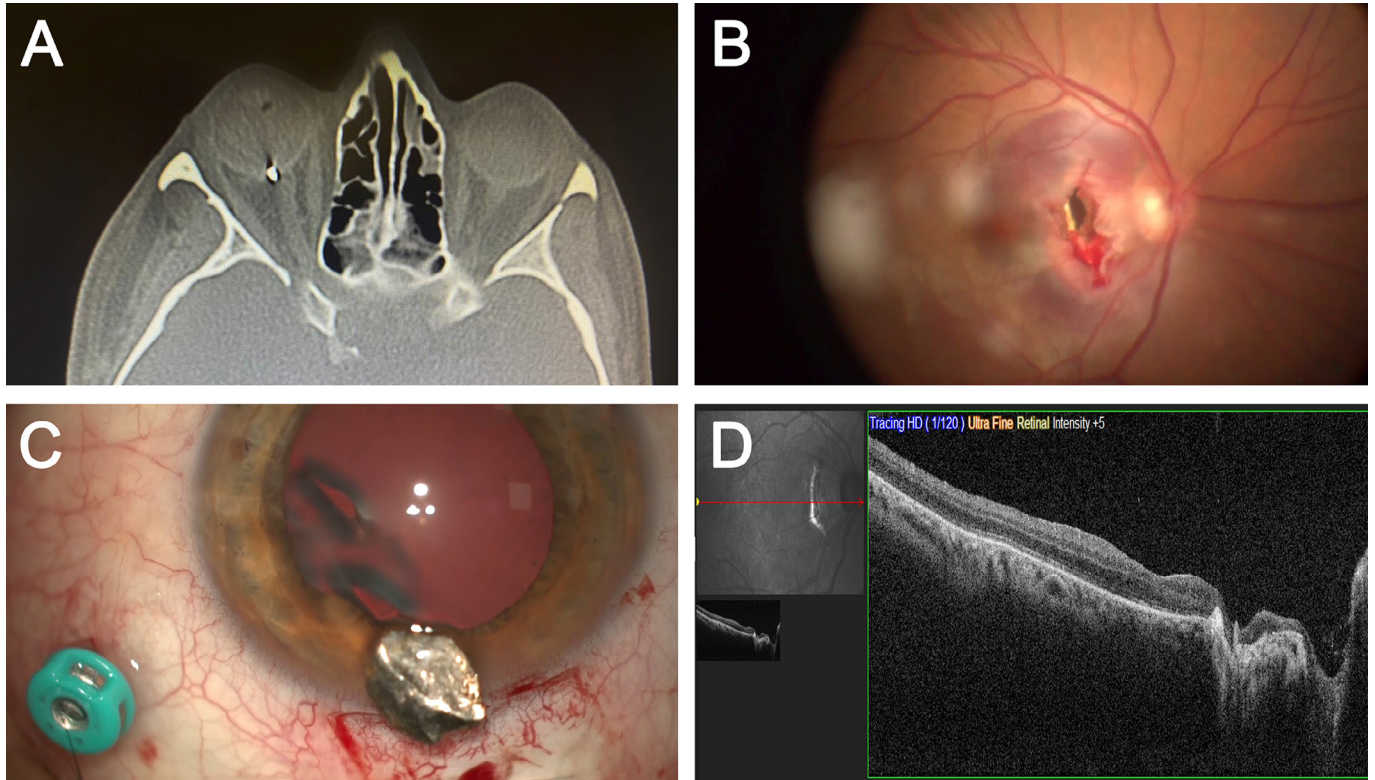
(A): An intraocular foreign body perforated the posterior pole between the optic disc and the macula and was located between the globe and the retrobulbar area, according to computed tomography; (B-C) The 6*5 mm sharp-edged intraocular metallic foreign body was captured with a single attempt by advancing through the posterior pole defect with ERM forceps, without missing the retrobulbar space and removed through a 6 mm pars plana incision; (D) Closure of the full-thickness posterior pole defect on the papillomacular bundle in the eighth postoperative month optical coherence tomography (OCT) image.
